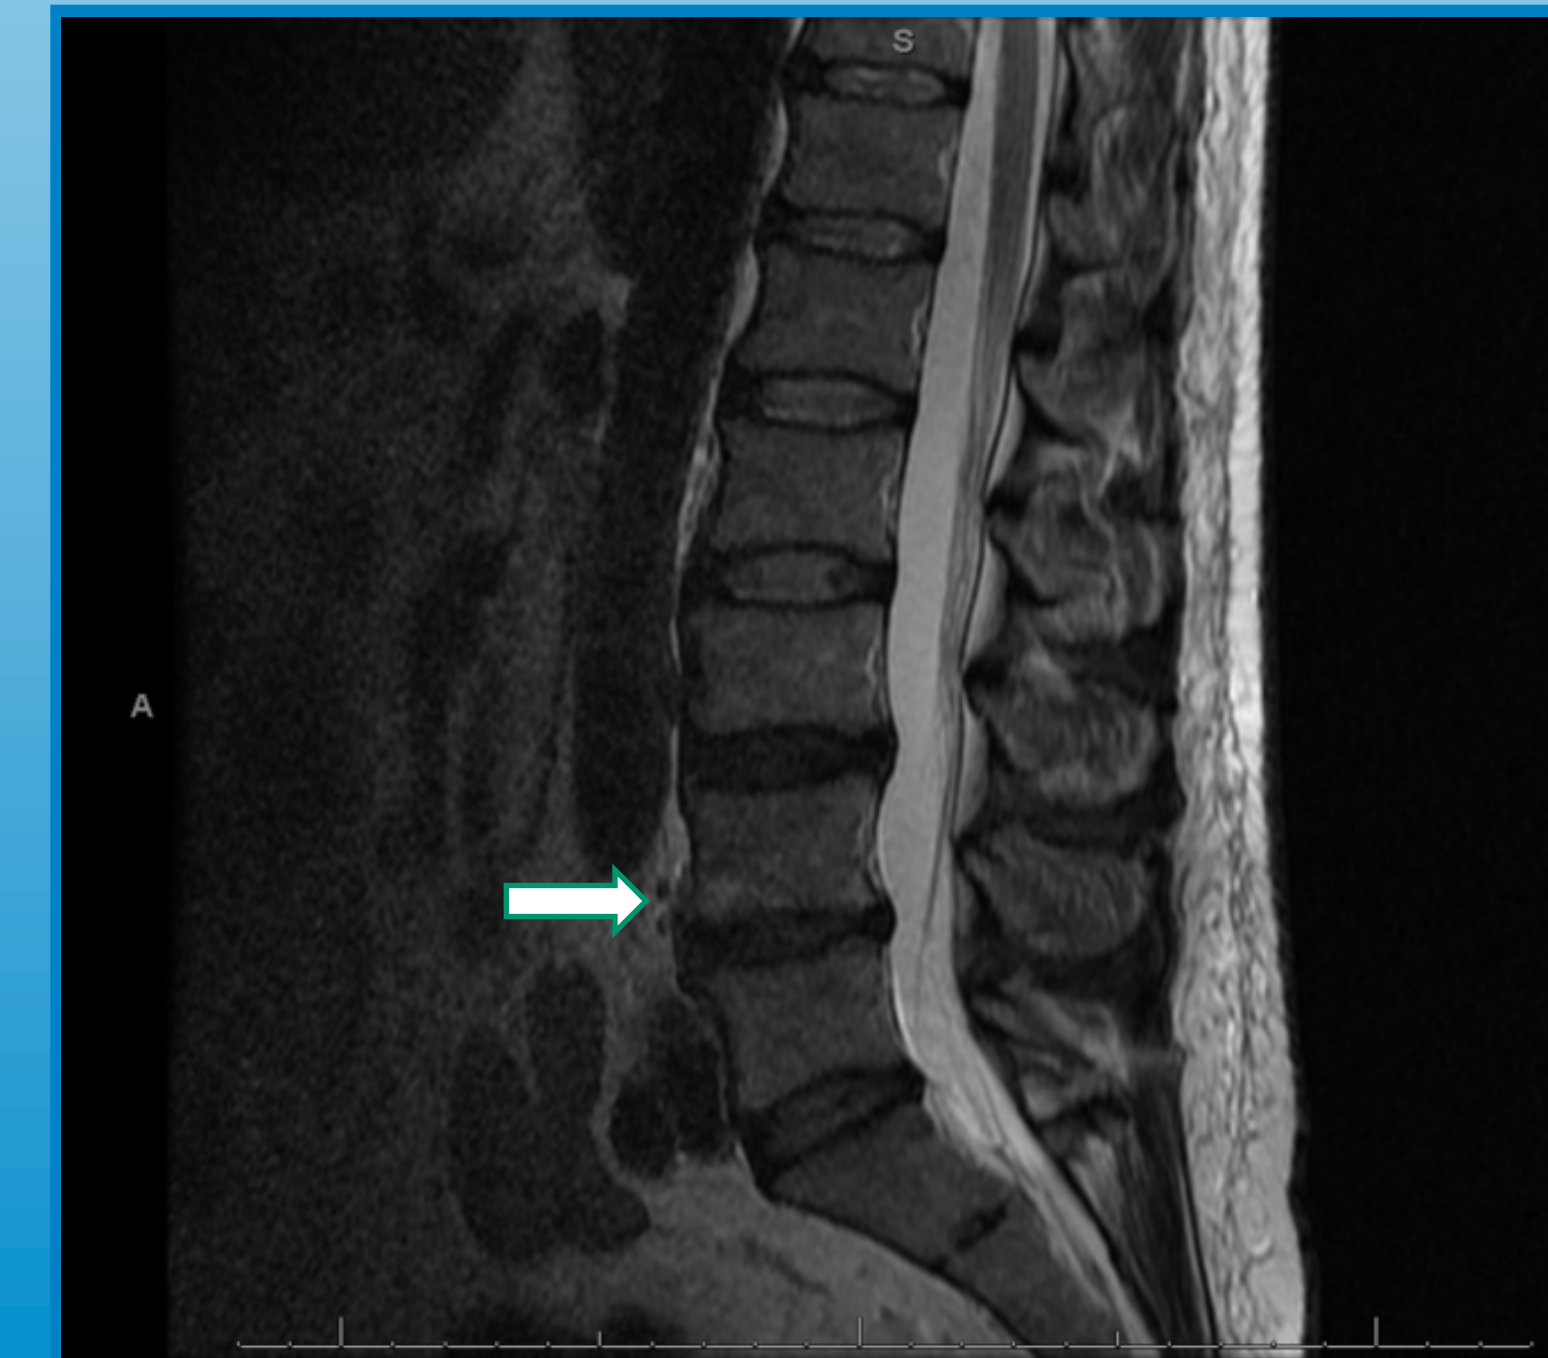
MRI of the spine with contrast showing a small osteomyelitis of L4 vertebrae at the anterior/inferior corner (as noted by the white arrow).
